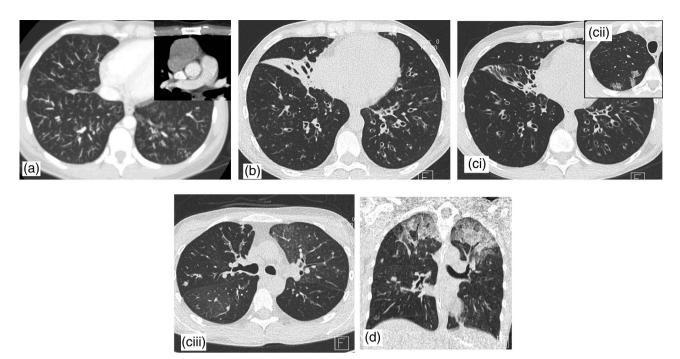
(a) Baseline computed tomography (CT) scan; diffuse tree-in-bud pattern, 3 mm maximum intensity projection (MIP) reconstruction. Thymoma in the anterior mediastinum. (b) CT scan three months after RT (five months after thymectomy); bronchiectasis, same tree-in-bud pattern, and right middle lobe atelectasis. (c) CT scan 17 months after radiotherapy (RT); progression of bronchiectasis (ci), small areas of ground-glass opacity (GGO) (cii), and large areas of air trapping in expiratory scans (ciii). (d) CT scan at respiratory failure, 20 months after RT (8 days before lung transplantation (LTx); areas of GGO in previously normal aerated lung
